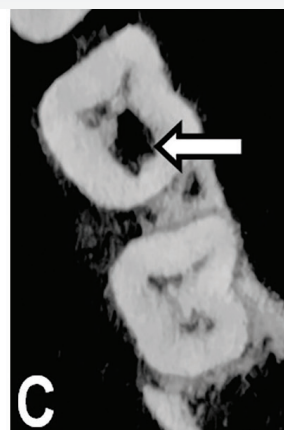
Preoperative axial CBCT image showing the size of the IRR at the level of the pulp chamber (arrow)
